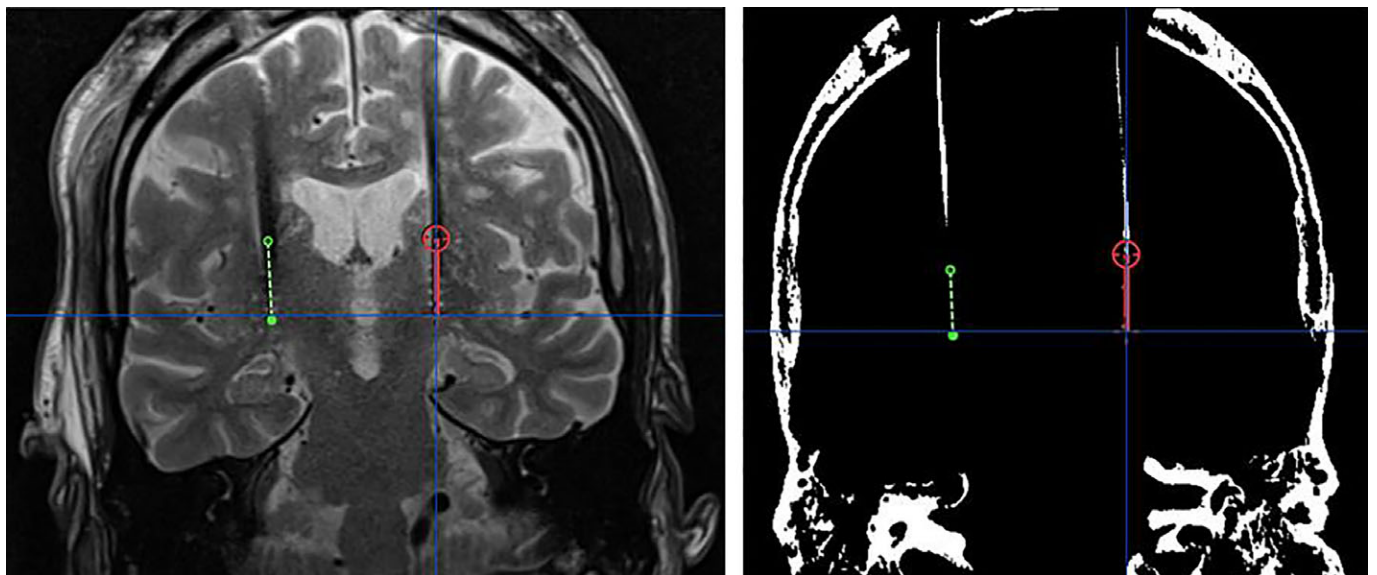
Lead visualization and plotted lead trajectory on MRI (left) and iCT (after windowing; right) in the same patient using the probe view in iPlan. The red and green lines represent the left-sided and the right-sided lead-artifact, respectively. [Color figure can be viewed at wileyonlinelibrary.com]
